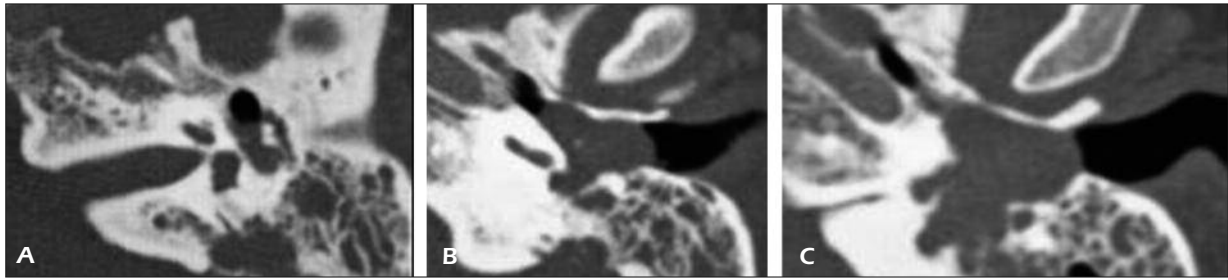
A-C, CT, axial plane. Maximum diameter of the mass about 2.5 cm with massive involvement of the mastoid and reaching the dura of the posterior cranial fossa.
